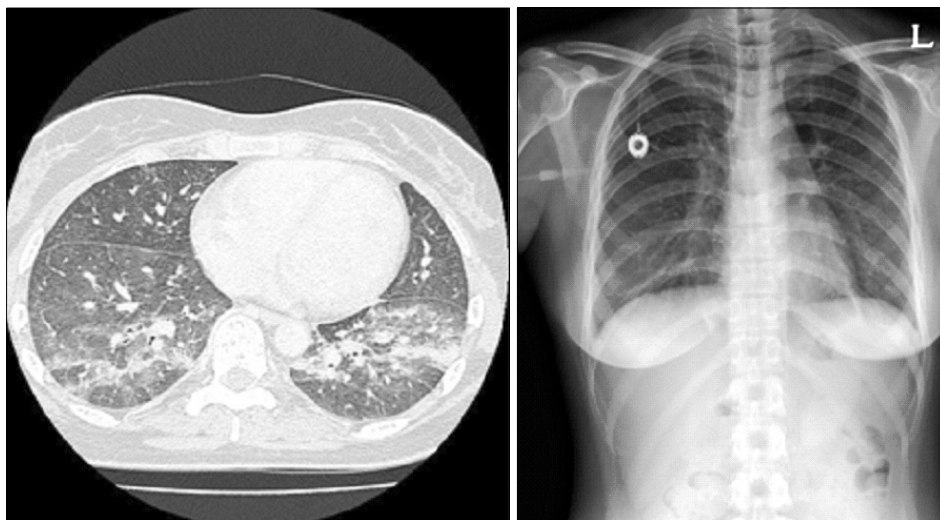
Rituximab-induced interstitial pneumonitis in chest HRCT scan and radiography.
